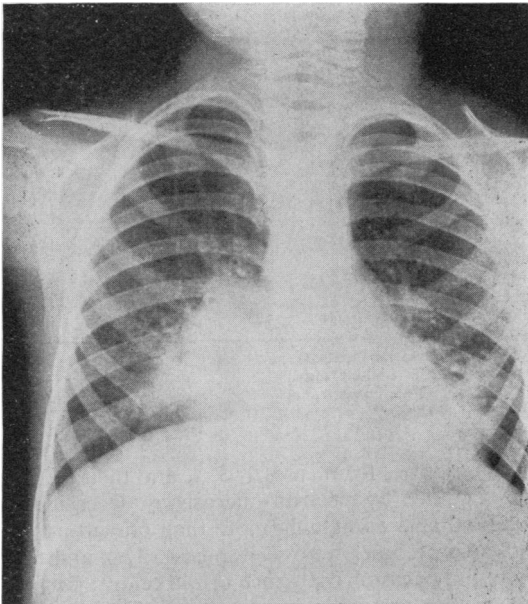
Chest radiograph of patient 3. There is bilateral consolidation involving both lower lobes, middle lobe, and lingula.
